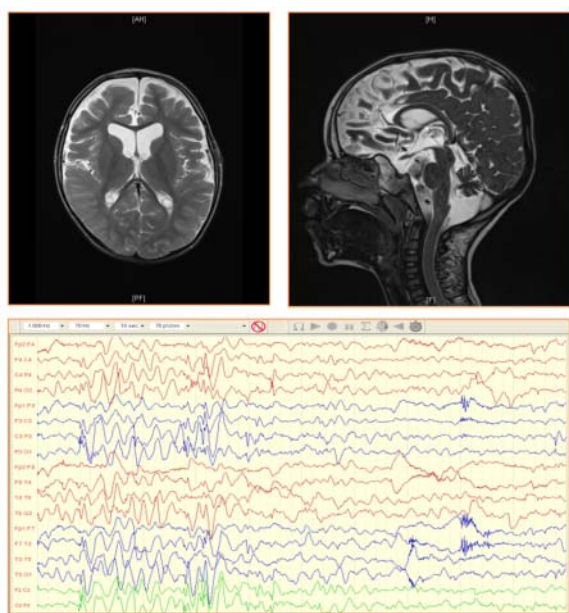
Patient 3111, aged 7 years. Upper panel: Axial and mid-sagittal T2 MRI showing cerebellar (vermian) atrophy and paucity of white matter. Lower panel: Awake electroencephalogram; bipolar montage demonstrating slow background activity and multifocal spikes.
